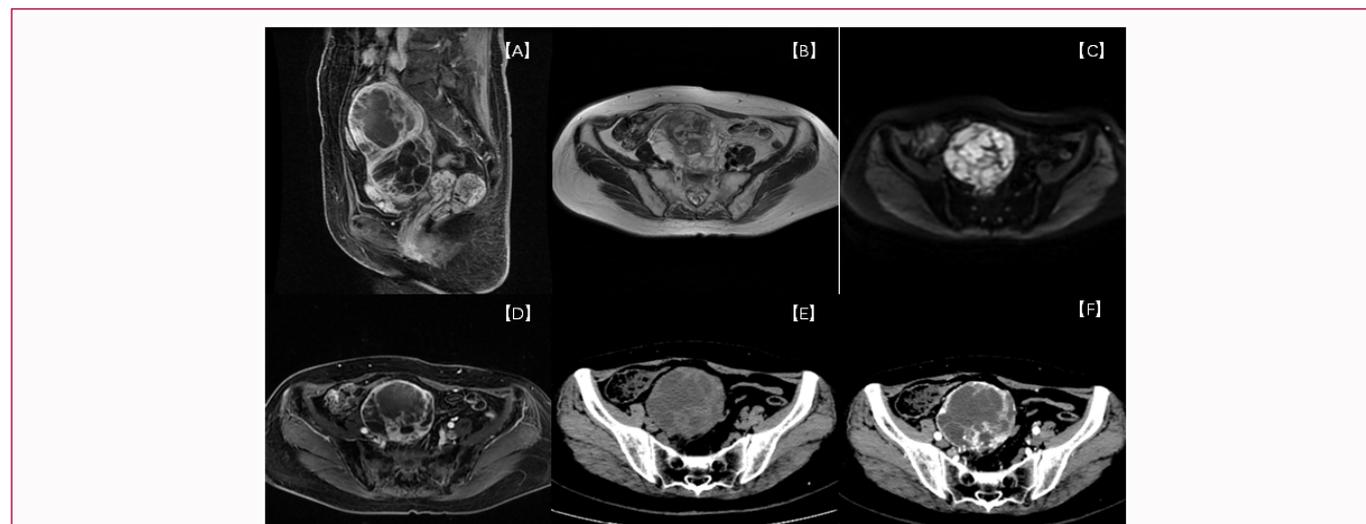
Preoperative imaging findings. MR (ABCD) and CT (EF) images showed an irregular mass in the pelvic cavity with a large cross section of about 86 mm × 76 mm × 129 mm, after intravenous injection of contrast iodine. The solid components and separation of the mass were significantly enhanced.
